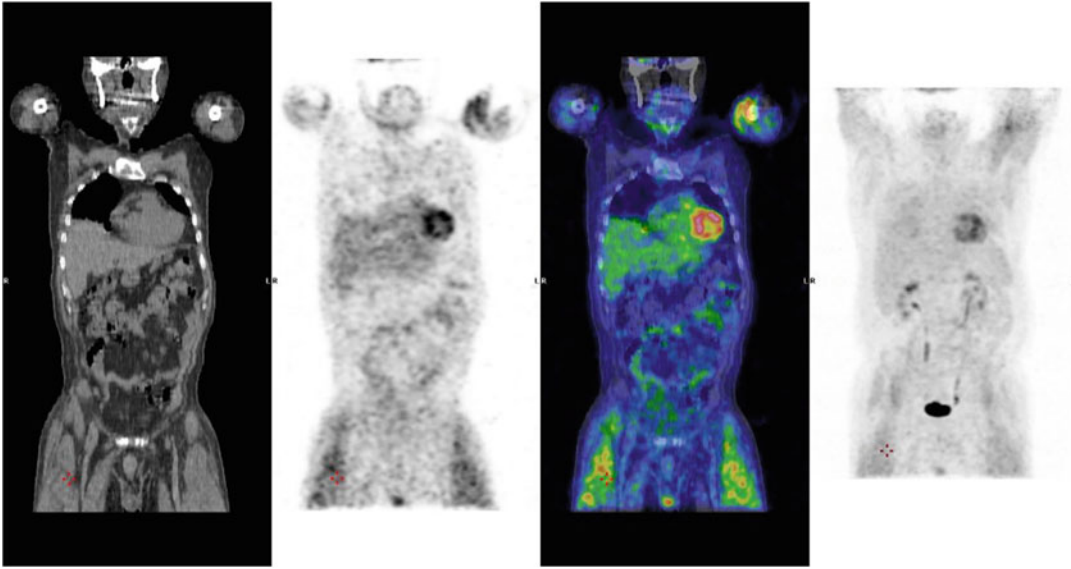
[18F]FDG PET/CT scan performed for restaging of Hodgkin lymphoma after 6 cycles of chemotherapy in a 65 years old diabetic patient treated with short acting insulin. High muscular [18F]FDG uptake is visible in particular in quadriceps muscle
